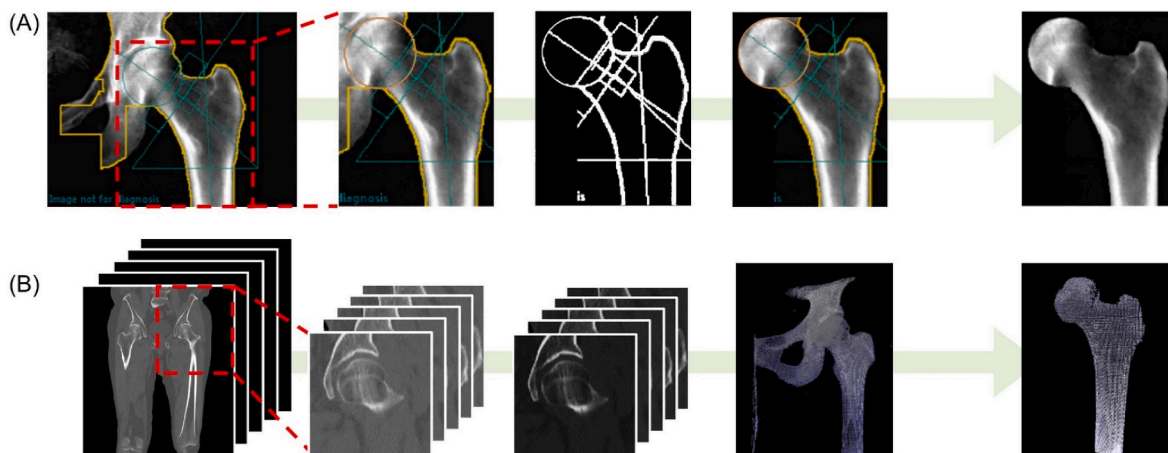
Femur segmentation from DXA and CT scan images. (A) DXA scan segmentation (B) CT scans segmentation. DXA, dual-energy X-ray absorptiometry; CT, computed tomography.
